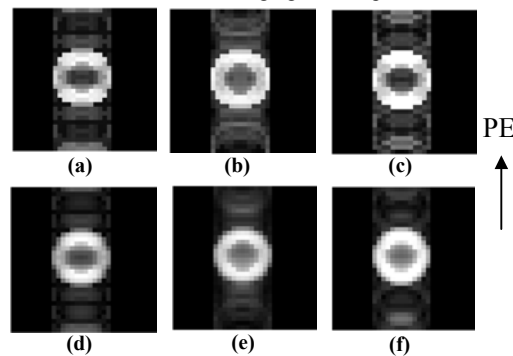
(a-c): DWI-PGSE; (d-f): DWI-DDF. The motion amplitude is constant (2.0 mm for DWI-PGSE, 4.0 mm for DWI-DDF), and the motion frequencies are 1.25 Hz (a,d), 1.58 Hz (b,e), and 2.10 Hz (d,f), respectively.
